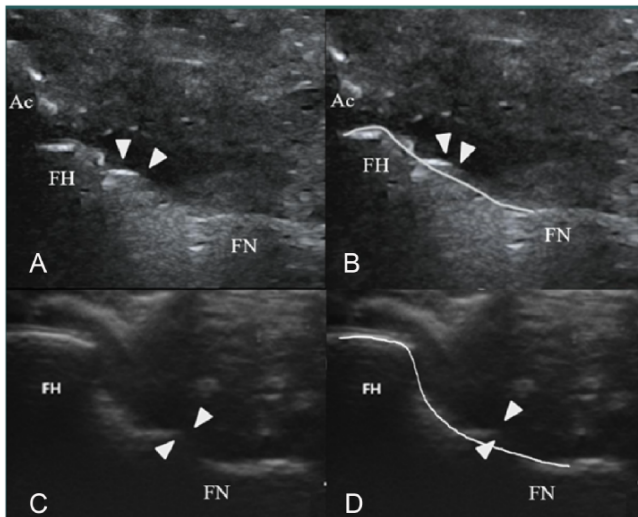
Residual cam deformity under ultrasound. After the first osteochondroplasty, the residual cam deformity (arrowhead) presented as a distinctly irregular contour (A), and bony protuberance (C) was found under ultrasound. (B) and (D) White lines indicate the ideal FHNJ morphology, and the bone above the line indicates the residual cam deformity.
